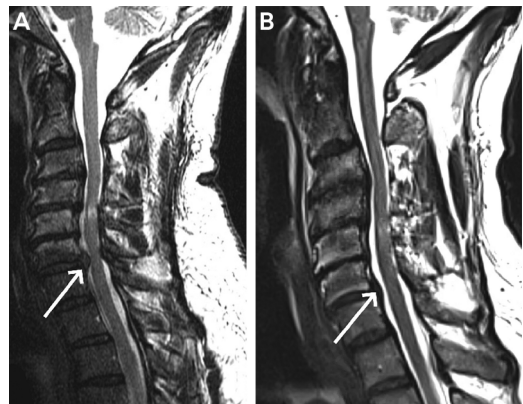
Imaging of the patient in CASE 7-2. A, Sagittal T2-weighted MRI shows an area of T2 cord hyperintensity at C4-C5 and disk protrusion causing severe canal stenosis at C6-C7 (arrow). B, Repeat sagittal T2-weighted MRI obtained 3 years later shows resolution of the prior disk protrusion at C6-C7 (arrow) without surgery.
